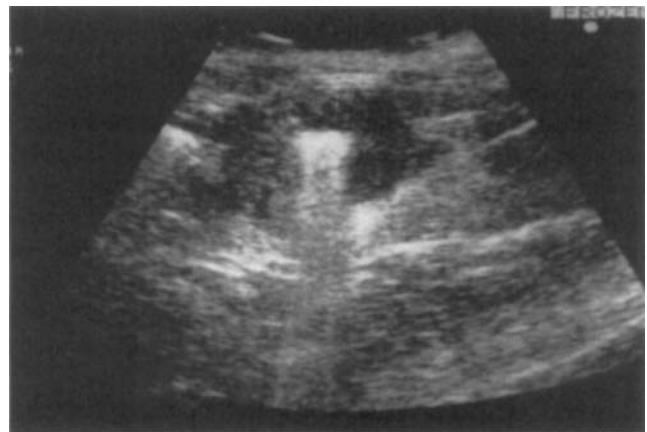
Transverse ultrasound image of the small intestine. Note the disruption of intestinal wall layering and the presence of bright central luminal echoes with distal reverberation (intestinal lymphosarcoma).
